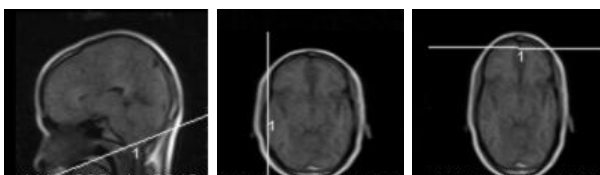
Views of MRI: Axial, Coronal, Sagittal
